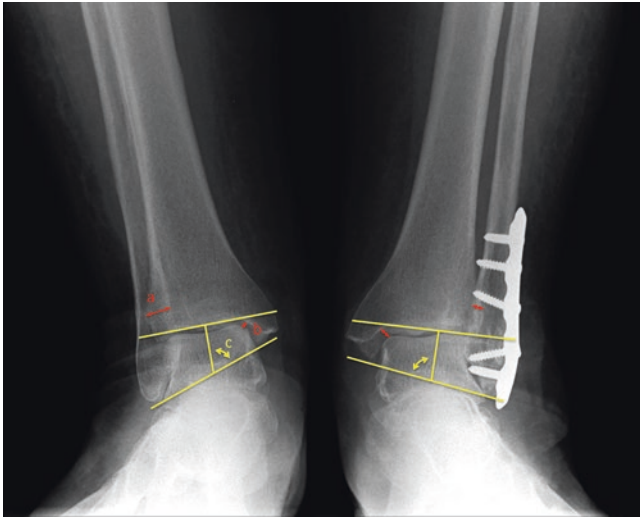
Comparing bilateral weightbearing AP ankle views: medial clear space (b) and tibiofibular overlap (a) of the ankle mortise view should be symmetric. Fibular length may be assessed by comparing the symmetry of talocrural angles, which is the medial intersection of a perpendicular line from the tibial plafond to the intermalleolar line (c). All radiographic values are increased on the *right*
